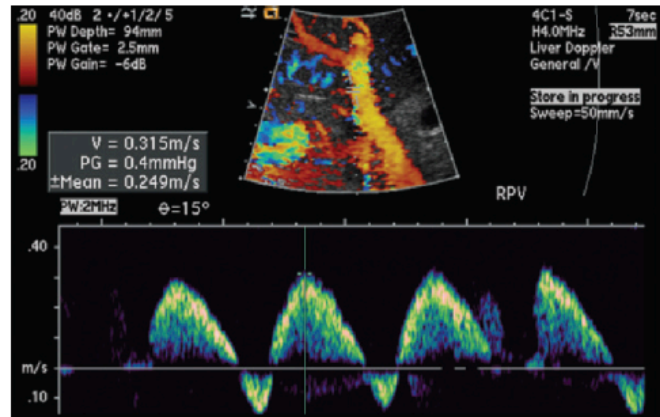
Spectral Doppler US image shows a pulsatile waveform with flow reversal in the right portal vein. The waveform may be systematically characterized as predominantly antegrade, pulsatile, biphasic-bidirectional, and di-inflectional.
